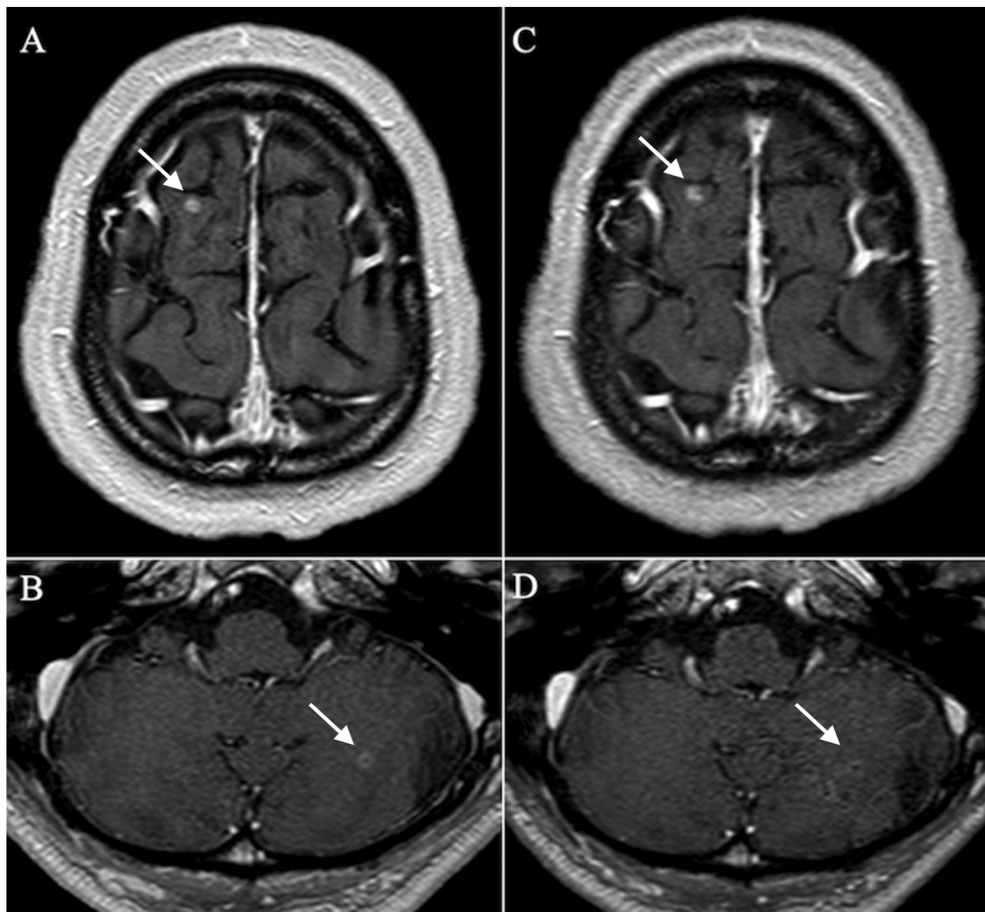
MRI findings. (A and B) Brain contrast-enhanced MRI at diagnosis revealed a metastatic brain tumor in the right frontal lobe and cerebellar hemisphere lesions (white arrows). (C and D) Brain-contrast MRI conducted after admission revealed no signs of encephalitis or meningitis, such as contrast enhancement at the brain and meninges. The existing lesions regressed after γ -knife irradiation, with no subsequent progression (white arrows). MRI, magnetic resonance imaging.
